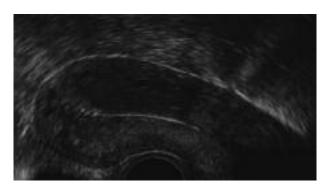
Vaginal ultrasound of FibroPlant® LNG-IUS (courtesy of Dr. D. Janssens).
